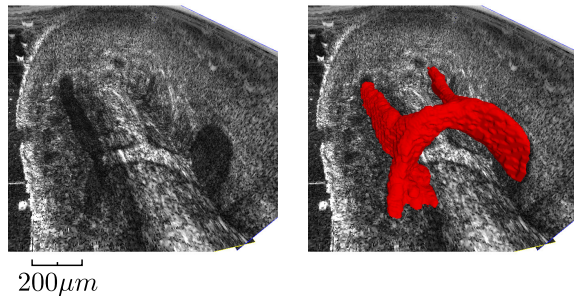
Segmentation of a vascular branching in the thumb on a 3D ultrasound image at 50MHz.
